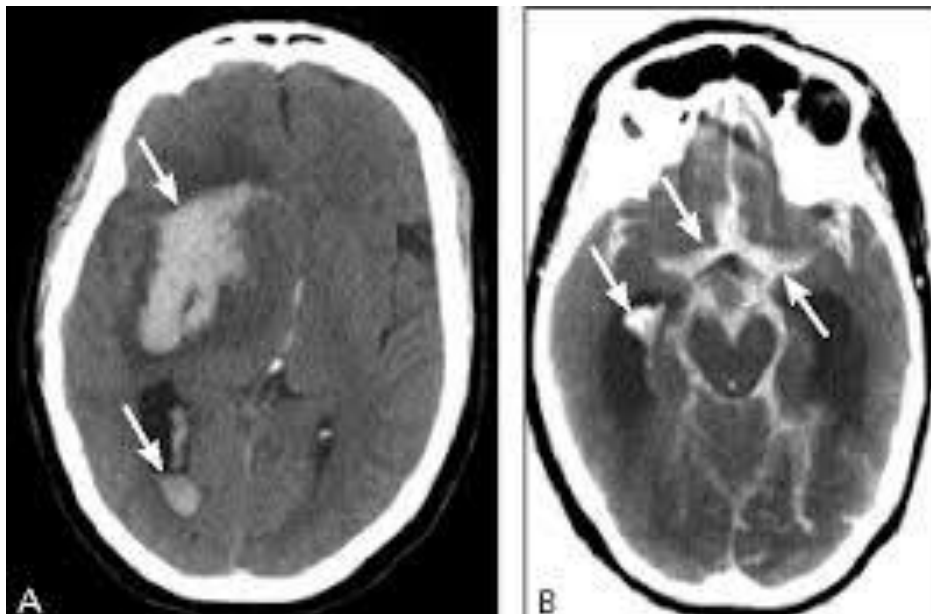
CT with intra-cerebral (A) and sub arachnoid hemorrhage(B)
